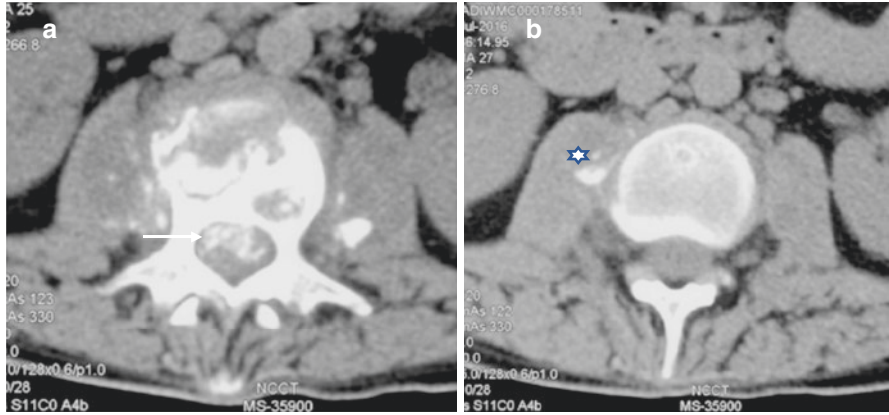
NCCT Axial section (a) through the lumbar region reveals fragmentary vertebral destruction with associated paravertebral collection showing calcification within. Destroyed bone fragments are also seen in the epidural space (arrow). Axial CT section at a lower level (b) showing a right psoas abscess with few specks of calcification (asterix)
